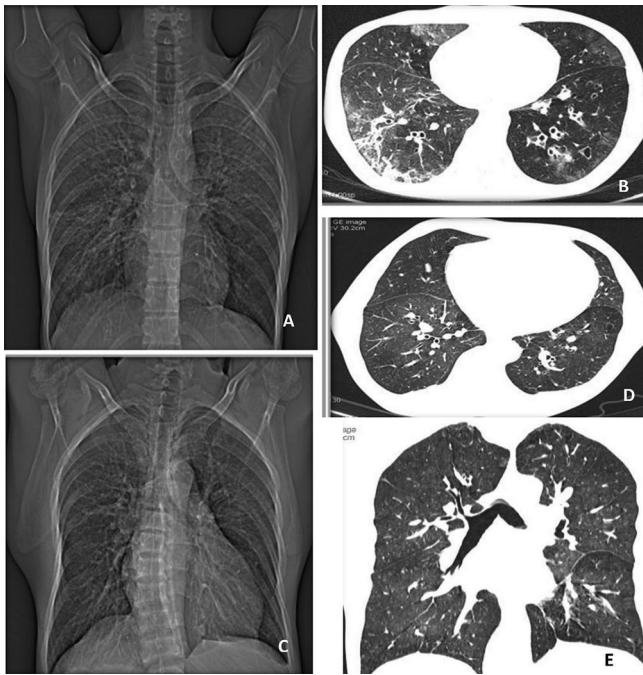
A & B. HRCT topogram and axial images of the male patient of age 21 yrs immunocompromised due to HIV infection showing “crazy paving pattern”. S/o *Pneumocystis jirovecii* pneumonia (fungal). C, D & E. HRCT topogram and axial images of a male patient of age 41 yrs immunocompromised due to renal transplantation and immunosuppressive drugs showing features resembling viral infection.
